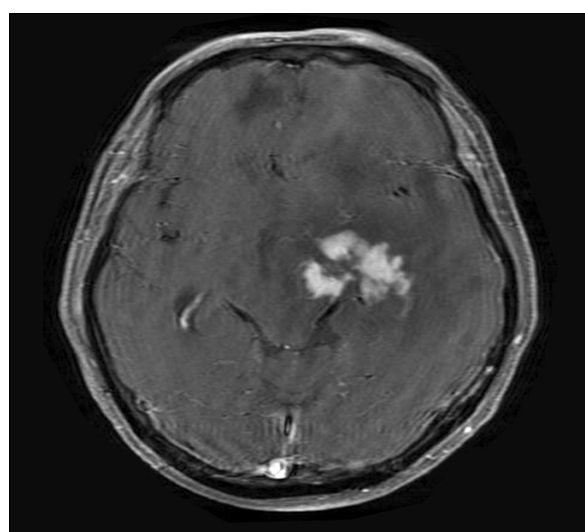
Brain magnetic resonance imaging shows brain tumor involved in left thalamus, basal ganglia, periventricular white matter, midbrain, pons, and middle cerebellar peduncle.
